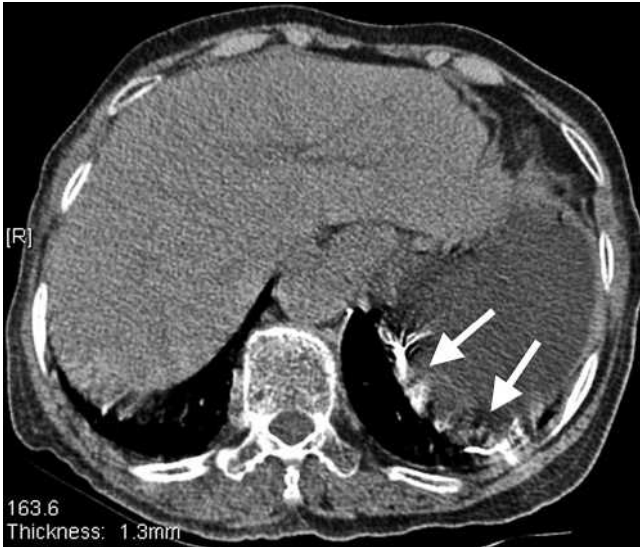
Abdominal computed tomography showed extravasation of sclerosant along the left subphrenic area (arrows).
